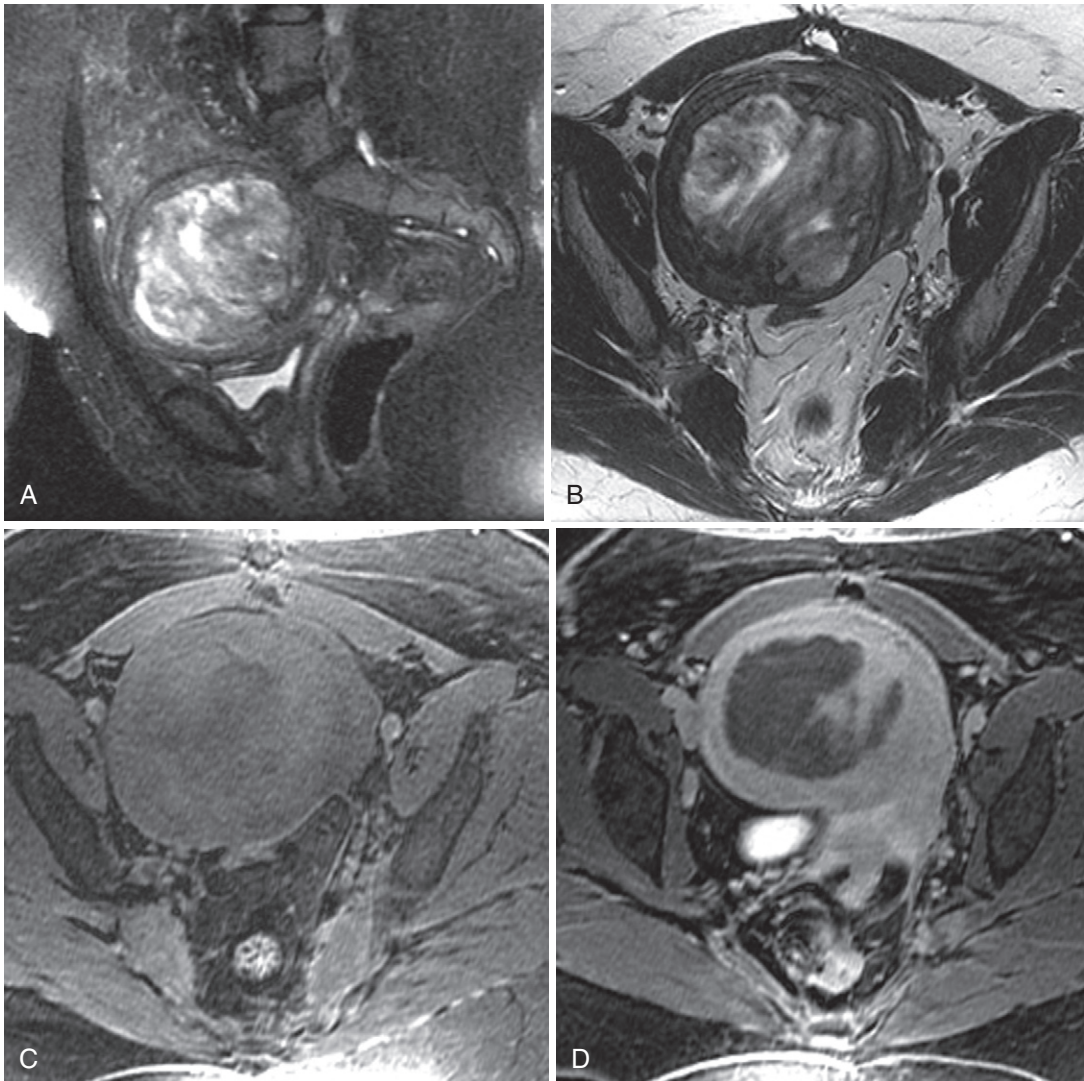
Fibroid with myxoid degeneration. Sagittal fat-saturated (A) and axial (B) T2-weighted images show heterogeneous hyperintensity throughout the large fibroid undergoing myxoid degeneration. Pre-gadolinium (C) and post-gadolinium enhanced (D) T1-weighted fat-saturated gradient echo images document an absence of enhancement indicating absent perfusion and degeneration.
